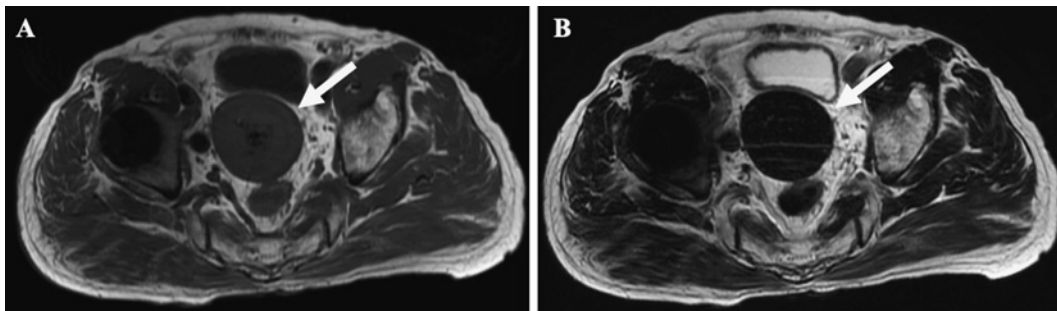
Magnetic resonance imaging findings. (A, arrow) T1-weighted imaging; (B, arrow) T2-weighted imaging. Both T1- and T2-weighted images show a mass and intensity similar to that of muscle tissue.
